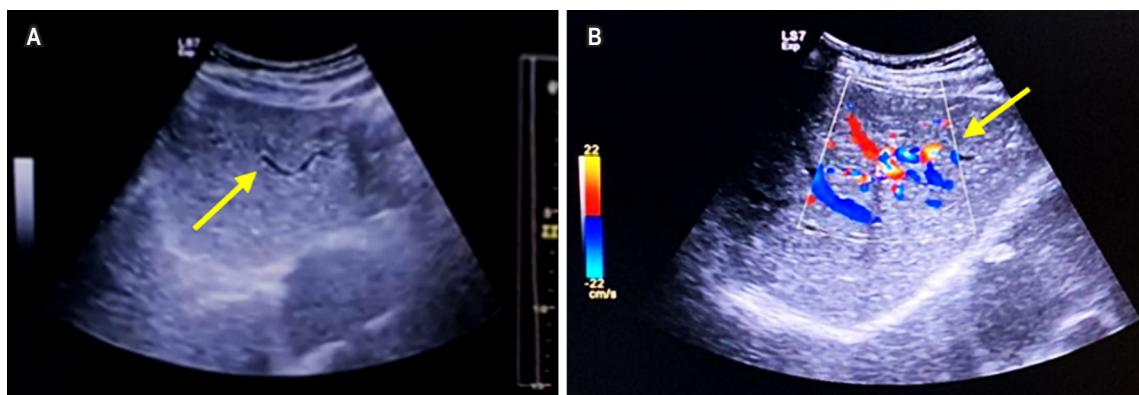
Portal Doppler ultrasound. A. Grayscale imaging showing serpentine-appearing vessels. B. Color Doppler enhancement of vascular structures. Images property of the authors.
